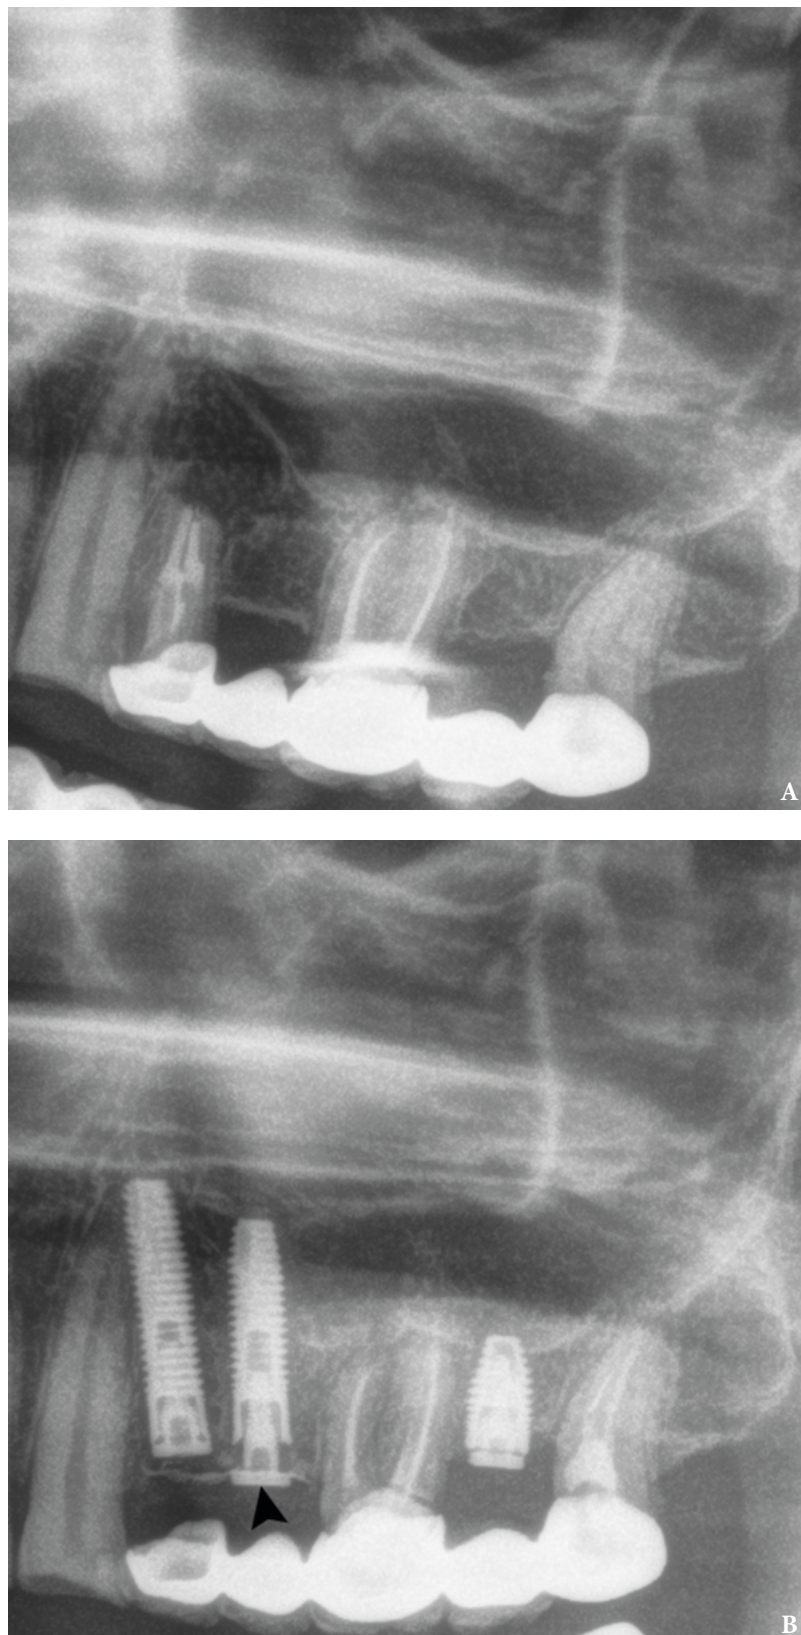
Preoperative (A) and postoperative (B) panoramic radiography. Cover screw that fixes titanium mesh is indicated by *arrowhead*.
